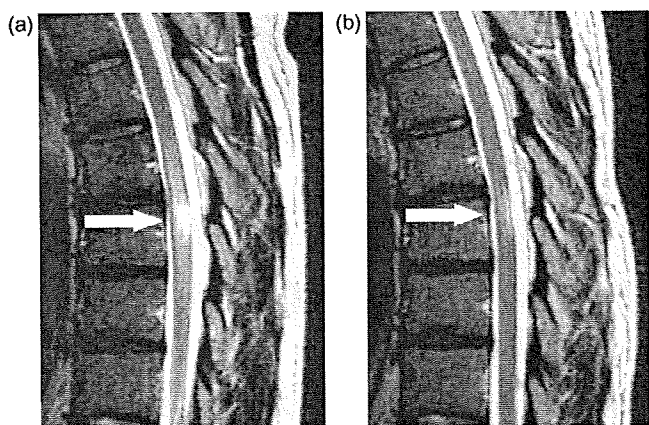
(a) T2-weighted MRI of the thoracic spinal cord before the onset of acute hepatitis. A high intensity lesion at the Th7-8 level with spinal swelling is observed. (b) T2-weighted MRI 2 months after discharge. The lesion of the spinal cord is diminished.
